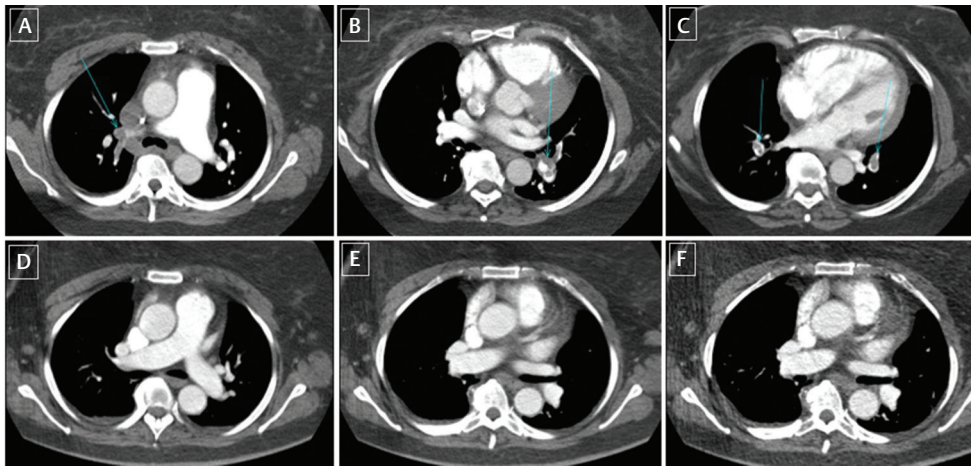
Representative initial (A–C) and 2-month follow-up (D–F) axial CT images for patient A. The initial CT images demonstrated large bilateral lobar PEs (arrows in A–C). The follow-up CT done at 2 months shows complete resolution of the emboli (D–F).
